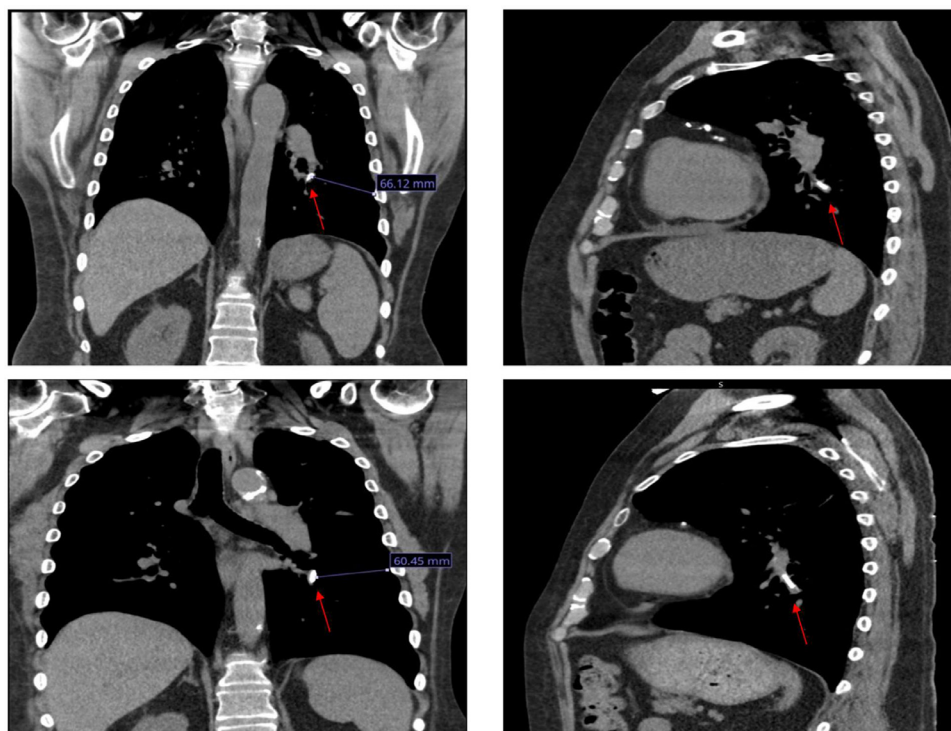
Sagittal versus coronal view of CT chest 6 years apart. Top images were taken shortly after original CardioMEMS device placement to confirm positioning, while bottom images were taken after migration of device to confirming inferior migration of the device 6 years later. Note positioning of the CardioMEMS device in reference to the 7th rib 6 years post-placement. The device appears more medial and superior to originally placed. This abnormal placement was first suspected by abnormal pulmonary artery waveforms first noted on the CardioMEMS device and reaffirmed via the images above and later confirmed via right heart catheterization.
